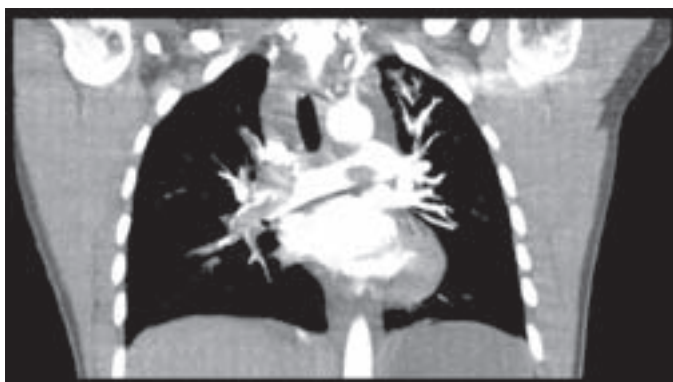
Axial view from a computed tomography (CT) angiogram which beautifully demonstrates a large saddle pulmonary embolus in a previously healthy female age 33 years who presented to the Emergency Department following a syncopal episode. She was not pregnant, and had mild chest pain, dyspnea, tachycardia, and tachypnea, which were not present before her episode.
